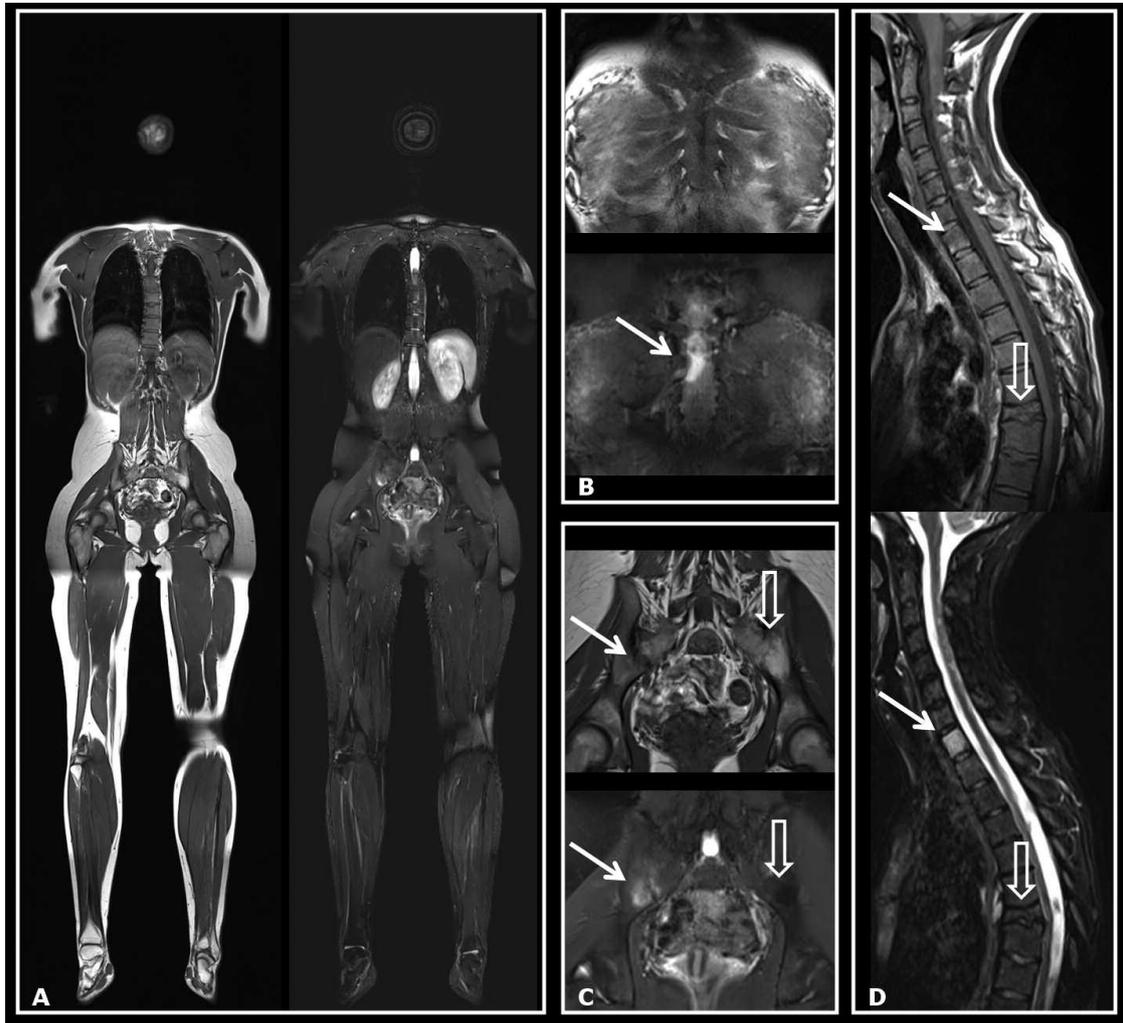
WB-MRI of a 19-year-old woman with a history of CRMO for longer than 10 years presenting with clinically symptomatic lesions in the sternum, the right sacroiliac joint, the right proximal humerus and femur, and the middle third of the thoracic spine. (A) Composed coronal whole-body images in T1 and STIR weighting. (B) Enlarged coronal images of the sternum in T1 and STIR weighting revealing a focal BME in the center of the body of the sternum consistent with a radiologically active lesion (thin white arrow). (C) Enlarged coronal images of sacroiliac joint revealing a focal BME at the inferior aspect of the right sacroiliac joint consistent with a radiologically active lesion (thin white arrows). A subtly pronounced fatty signal change adjacent to the left sacroiliac joint (broad hollow arrows) was not taken into account by the readers, but could represent a remnant of an old lesion. (D) Enlarged sagittal images of the cervical and upper thoracic spine show a global BME in the vertebral body Th1 consistent with a radiologically active lesion (thin white arrows) and a vertebra plana Th7 (broad hollow arrows). WB-MRI: whole-body magnetic resonance imaging; CRMO: chronic recurrent multifocal osteomyelitis; STIR: short-tau inversion recovery; BME: bone marrow edema.
